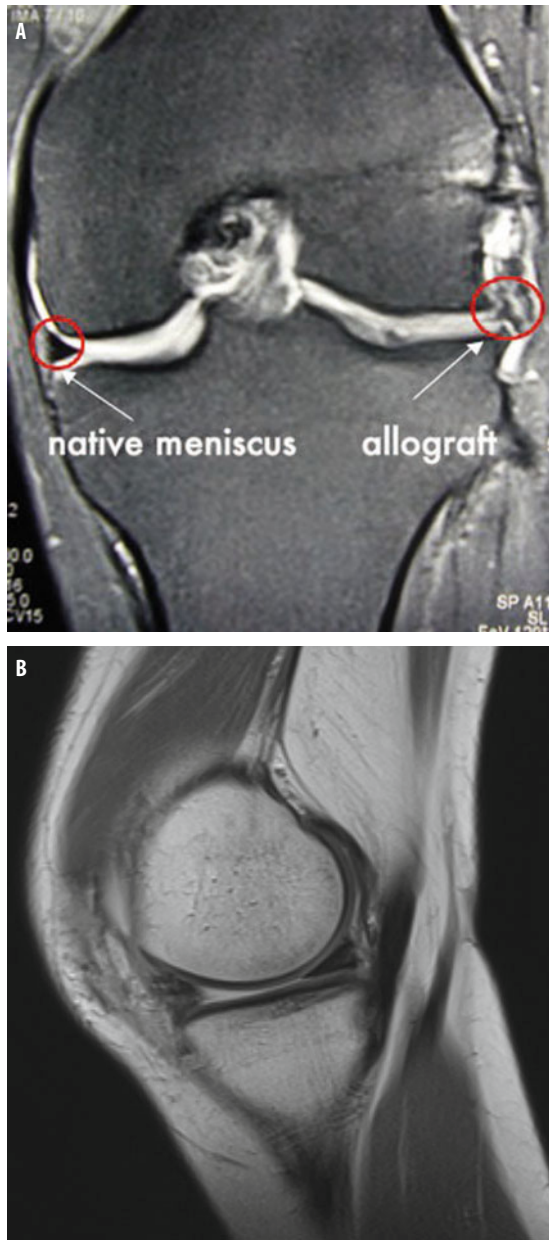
(A) MRI-image: extrusion of a lateral meniscal allograft and native medial meniscus in a left knee. (B) MRI-image: well-positioned medial meniscal allograft and native lateral meniscus in a right knee.
